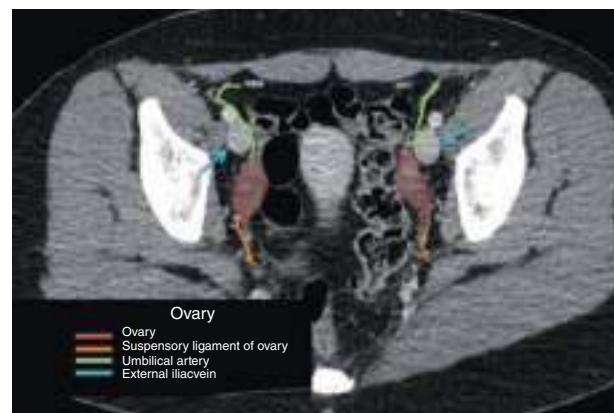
Ovary. Axial contrast-enhanced CT image (portal venous phase).
